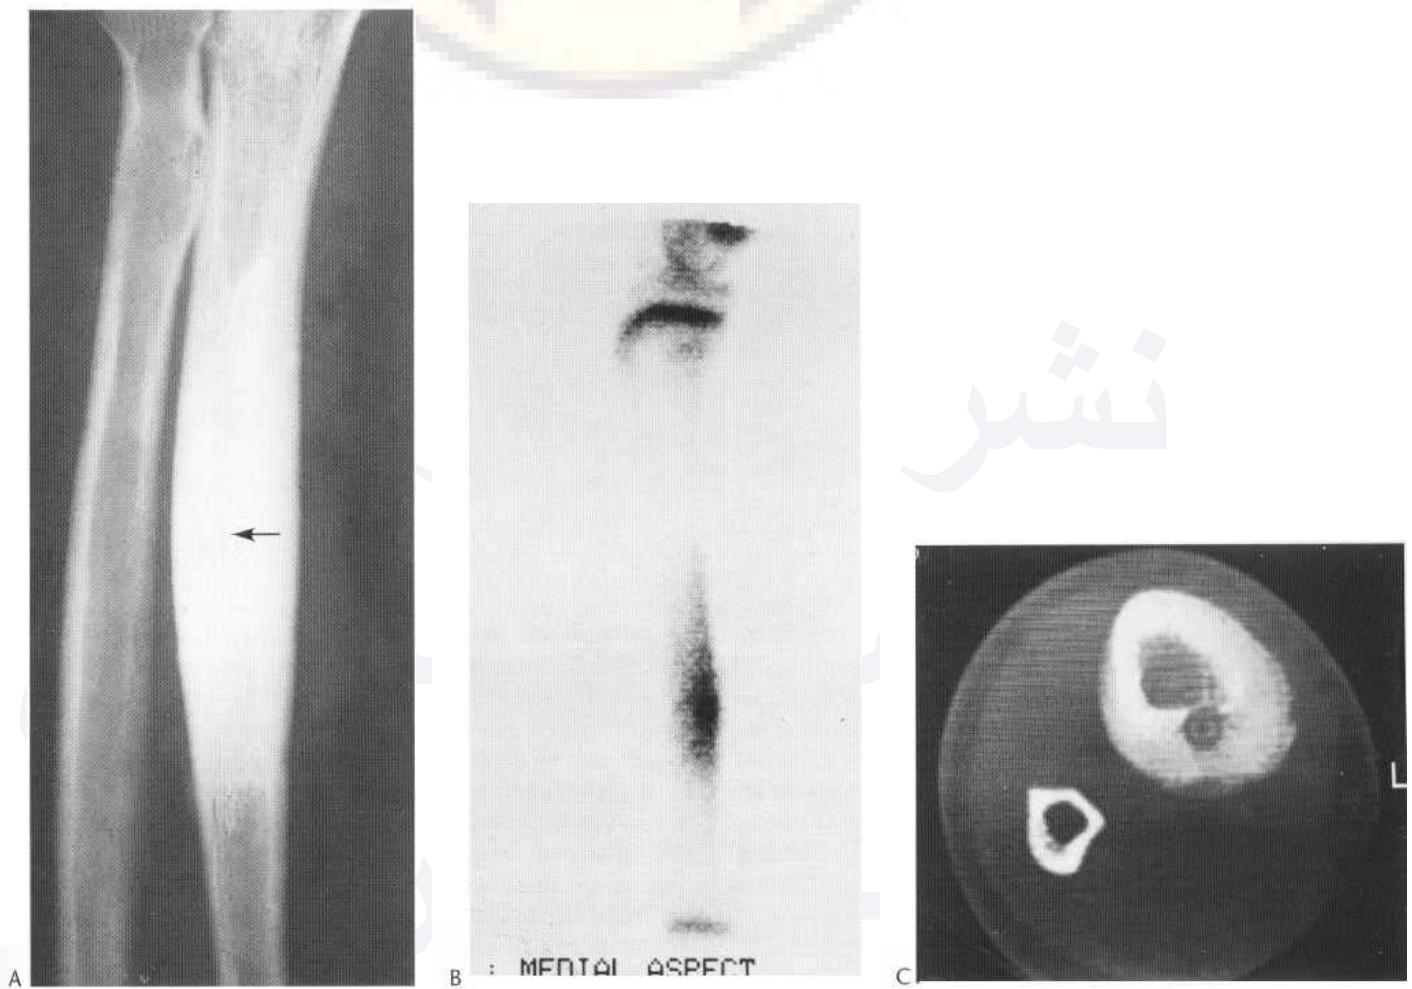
Osteoid osteoma. (A) Involving the ulna in a 13-year-old boy. The appearances are typical, with a well-defined area of radiolucency (arrow) containing a dense nidus. Extensive cortical sclerosis is present around the lesion. (B) Radioisotope bone scan in another patient demonstrating intense focal increased scintigraphic activity in the distal tibia surrounded by a more diffuse area of less intense activity, typical of an osteoid osteoma. (C) CT section of the tibial lesion elegantly demonstrating the cortically located nidus.
